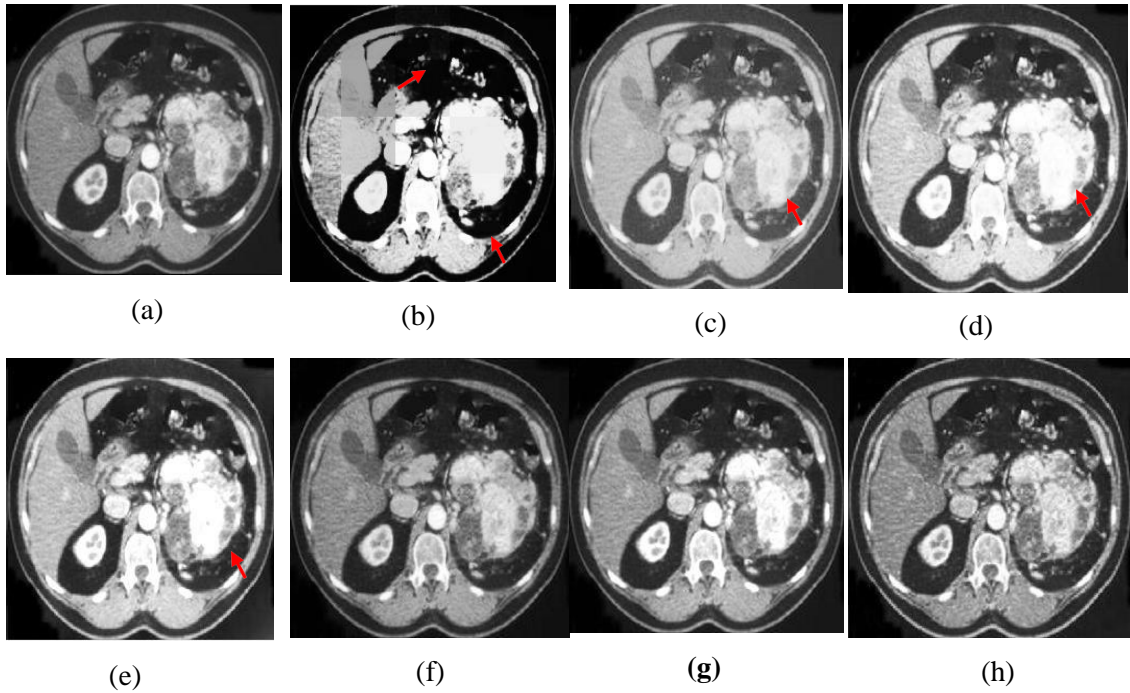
3.9 Input "CT-7" image and it's associated enhanced images (a) Input image, (b) S-curve, (c) AGC-DWT, (d) AGC- WHD, (e) GAGC-DWT, (f) EBCHE, (g) TCHE-DWT, (h) Proposed technique
